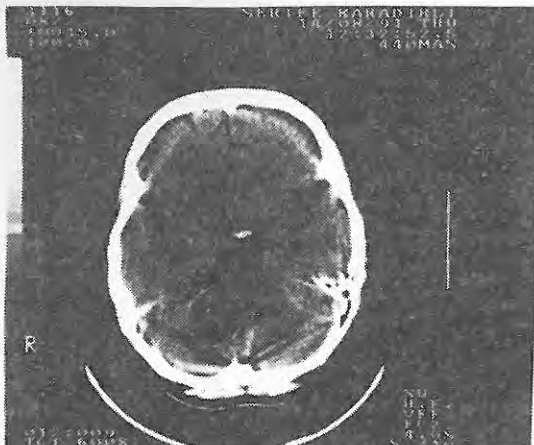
The second preoperative CT scan. The cyst diameter is 32.7 mm
